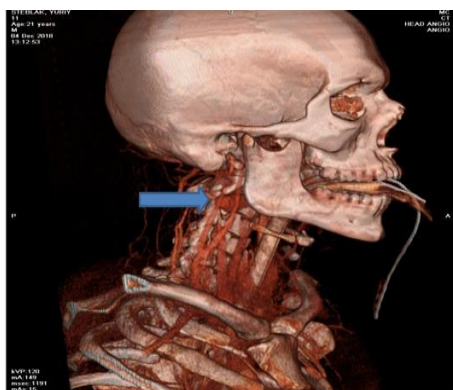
Head and neck CT with contrast enhancement. 3d reconstruction, side view
